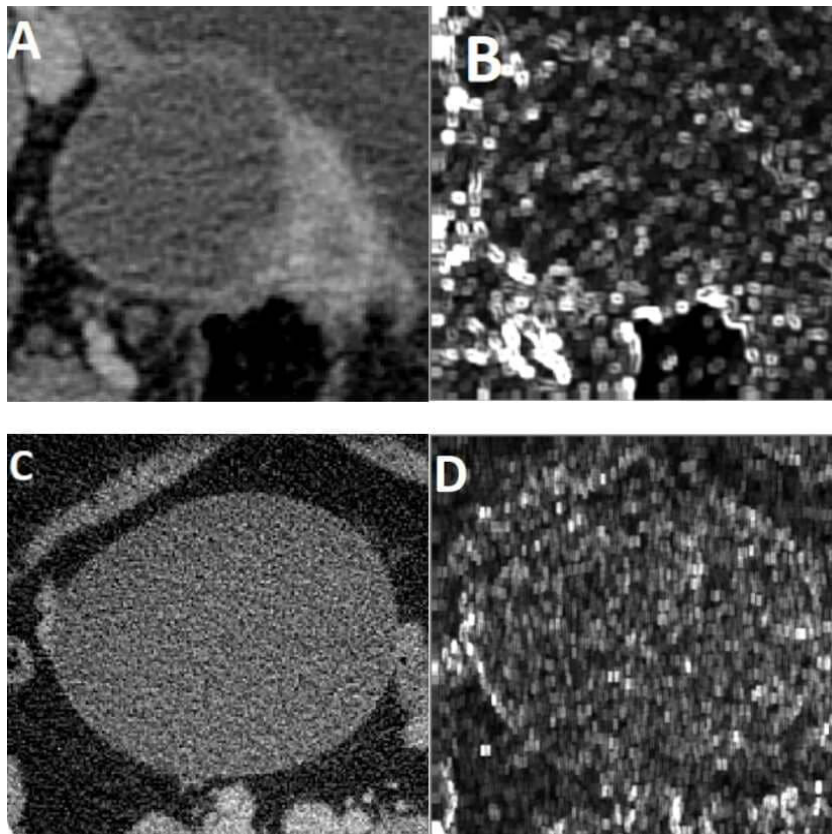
Generated maps showing differences between a malignant and a benign lesion. A) a contrast-enhanced computed tomography image on a 73-year-old patient with pathologically confirmed clear cell carcinoma; and B) generated map based on the $S(2,0)DifVarnc$ (difference variance) feature extracted from this lesion; C) a contrast-enhanced computed tomography image of a 42-year old patient with pathologically confirmed mucinous cystadenoma; and D) generated map based on the $S(2,0)DifVarnc$ feature extracted from this lesion.
